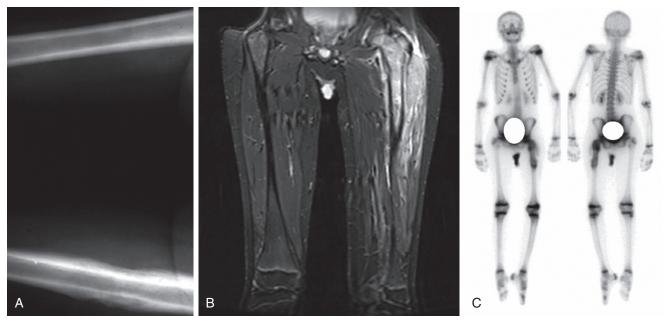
Ewing sarcoma. A, Plain x-ray of a child with Ewing sarcoma showing cortical destruction and soft tissue swelling of the diaphysis of the femur. B, MRI of the lower extremity further defining the tumor. C, Bone scan to evaluate the extent of disease, again limited to the primary site. (*A*, *Courtesy J. Medina, MD, Pittsburgh, Pa.*)
